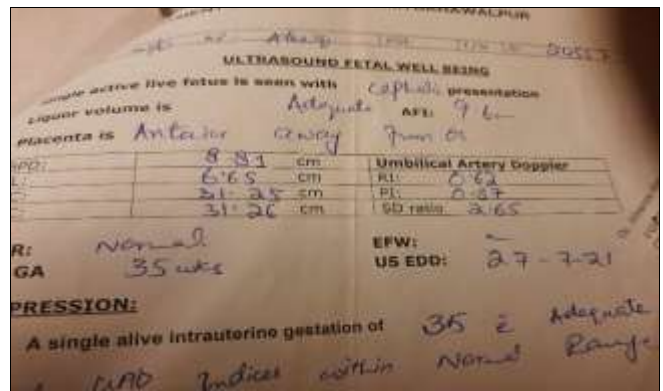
Showing Ultrasound Evidence of Current Pregnancy for Index Case 4
